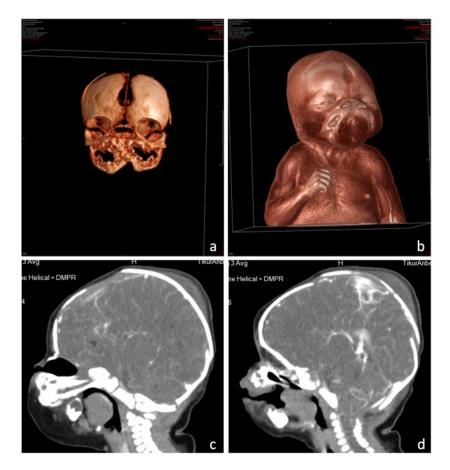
CT scan. VR (a-b) Duplication of the mandible and, partially, of the maxilla, double opening of the oral cavity.
